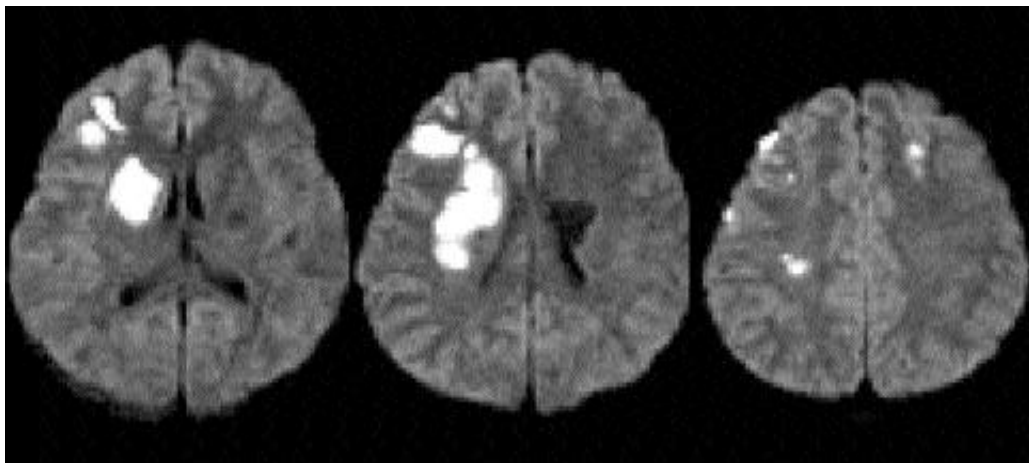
Magnetic resonance Imaging (MRI) of the patient. Brain MRI showed recent infarctions in the bilateral frontal lobes and the right basal ganglia.
